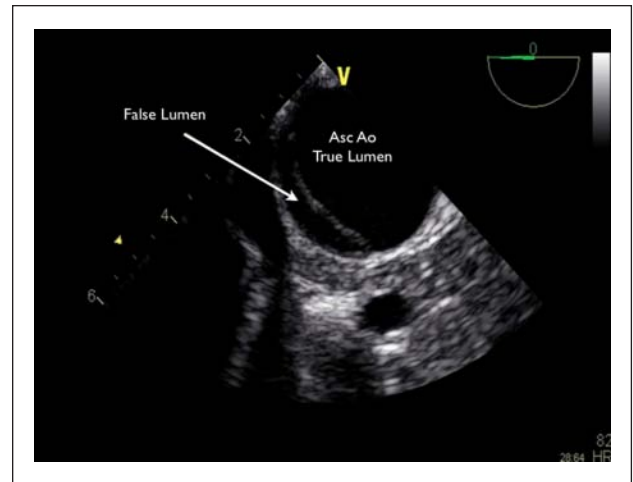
Transesophageal echocardiography short-axis view of an ascending thoracic aortic dissection
